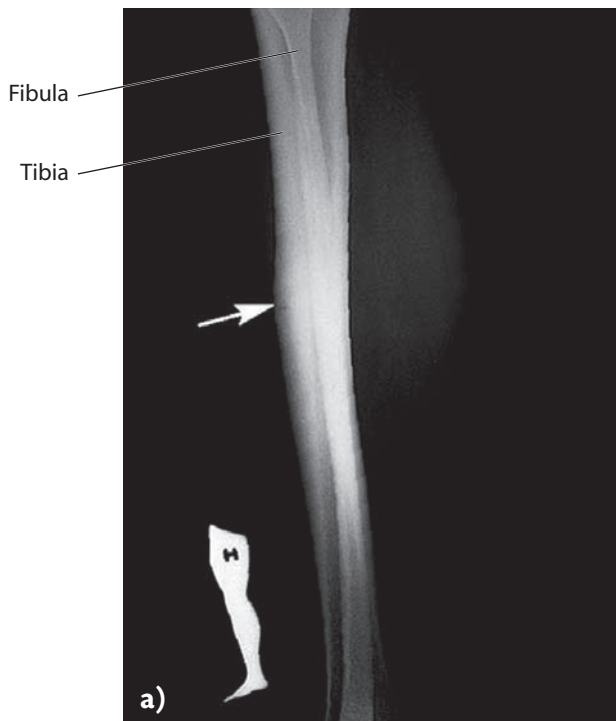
Objective forms of examinations for stress fracture of the tibia. a) X-ray shows the stress fracture on the anterior side of the tibia. Note the thickening (hypertrophy) of the anterior tibial edge (cortical bone); b) examination with radioactive isotopes scintigraphy. The black area shows the uptake.
